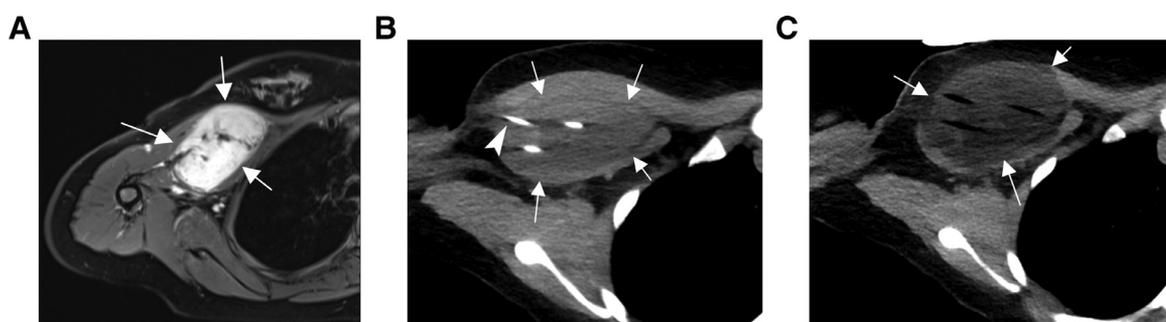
Adolescent female with history of right axillary desmoid under active treatment with chemotherapy, prior surgical debulking and cryoablation. T1 VIBE postcontrast with subtraction image (A) demonstrates a large well-circumscribed avidly enhancing soft tissue mass (arrows), diagnosed as a desmoid tumor. A total of 4 cryoablation probes were placed under ultrasound guidance to contour the treatment zone and preserve the neurovascular bundle. Axial CT (B) image demonstrates cryoprobes (arrowhead) within the mass (arrows). Postcryoablation axial CT image (C) demonstrate a well-formed ice-ball (arrows) extending over 80% of the lesion with preservation of the brachial plexus and axillary vasculature (at superior margin of lesion). (Images used with the permission of Dr. Michael Acord.)
